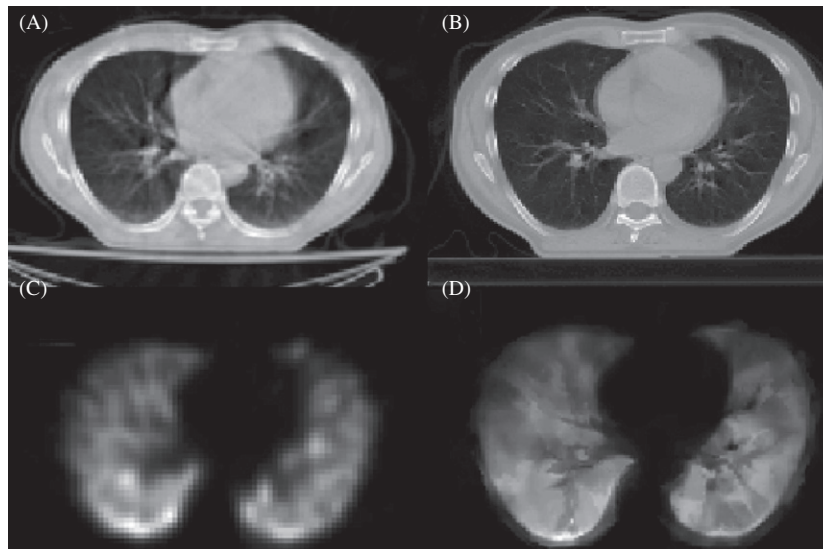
A sample of transversal slice in CT (A: *moving CT image*. B: *fixed CT image*) and SPECT images (C: *moving SPECT image*. D: *registered SPECT image* from level set registration). Invalid SPECT counts can clearly be seen in gray scale.
